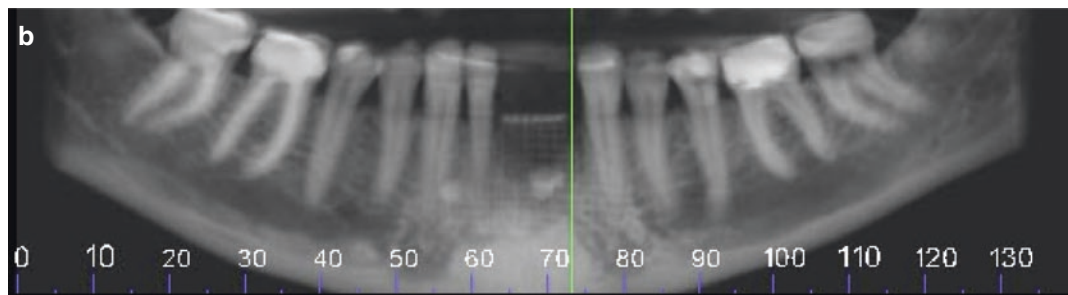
Clinical intraoral photograph (a) of a large combined vertical and horizontal defect in the anterior mandible with a compromised labial cortical plate. A mandibular biomodel was printed using CBCT presurgical data and a titanium mesh pre-sculptured to the desired
